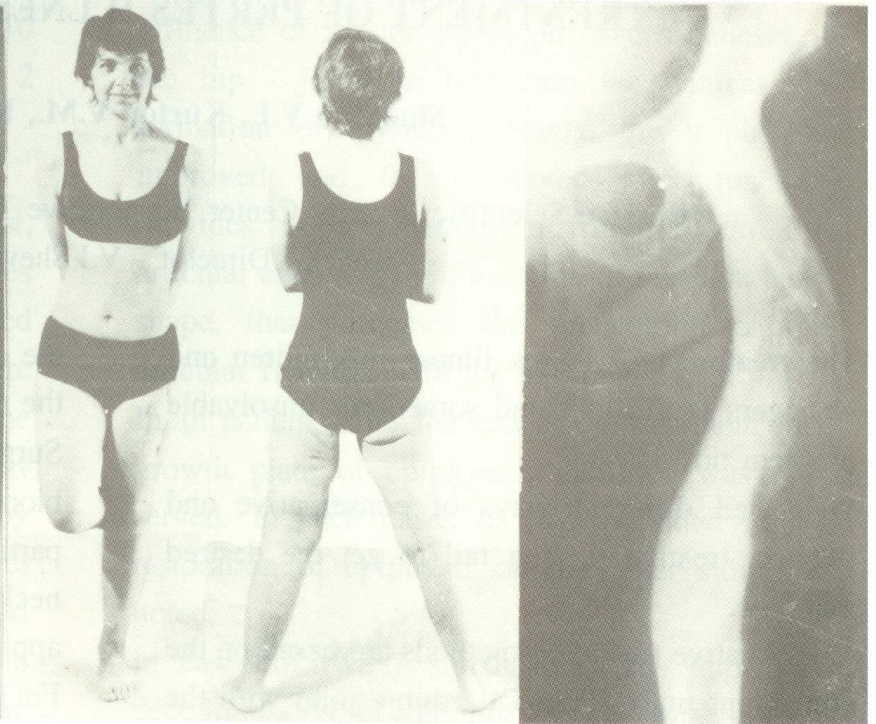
Patient and X-ray in 4 years after the apparatus removal
